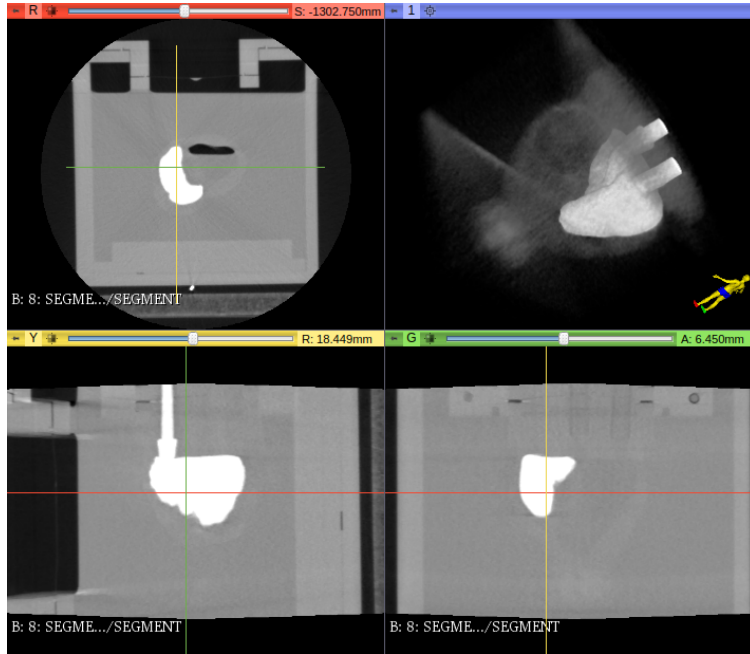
View of CT volume from 3D-Slicer. X-, Y-, and Z-plane, and a volume rendering.
